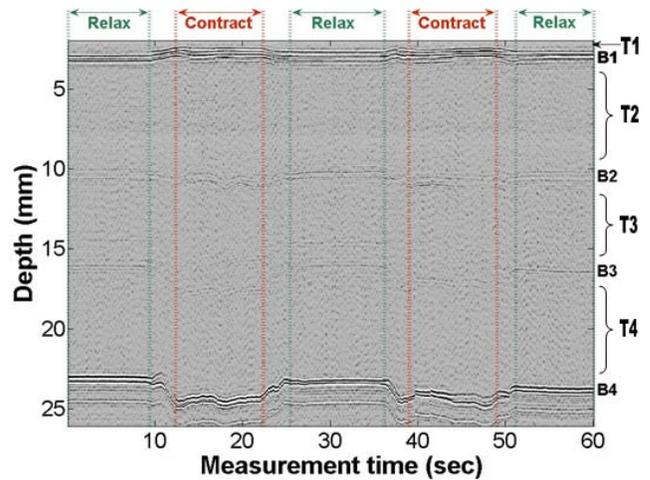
A result of M-mode ultrasound measurement at forearm.
